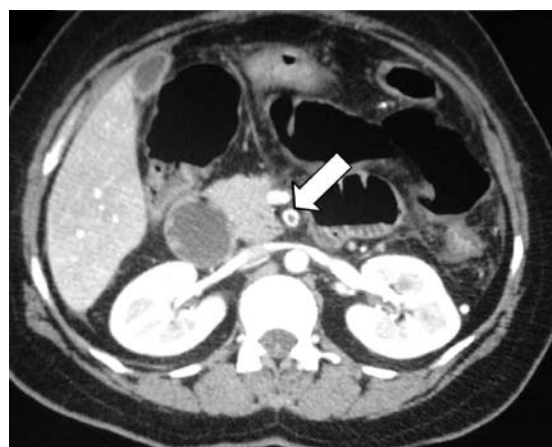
CT angiogram shows superior mesenteric artery thrombosis (arrow) in a 40-year-old woman.
